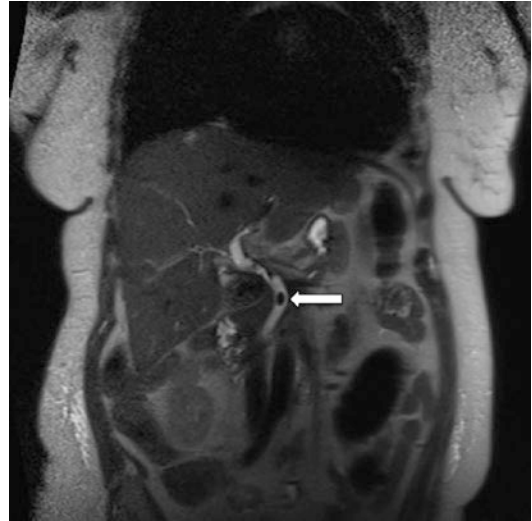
Diagnostic MRI quality with 1.5 T MRI coronal T2 weighted HASTE in a 120 kg patient. A calculus in the common bile duct is clearly demonstrated (*arrow*)
